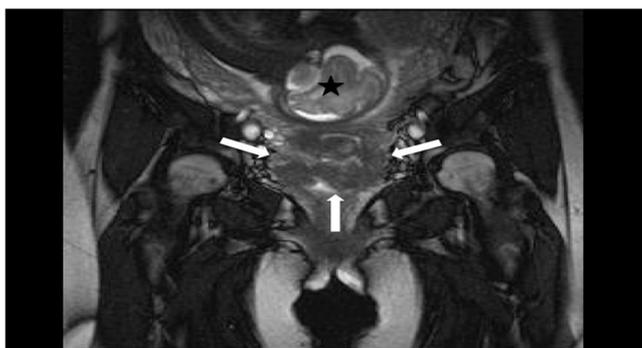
Coronal T2 weighted MR image shows cervical carcinoma invading the cervical stroma and minimally parametrium (arrows). Fetal head (asterix) is located above the cervix.
